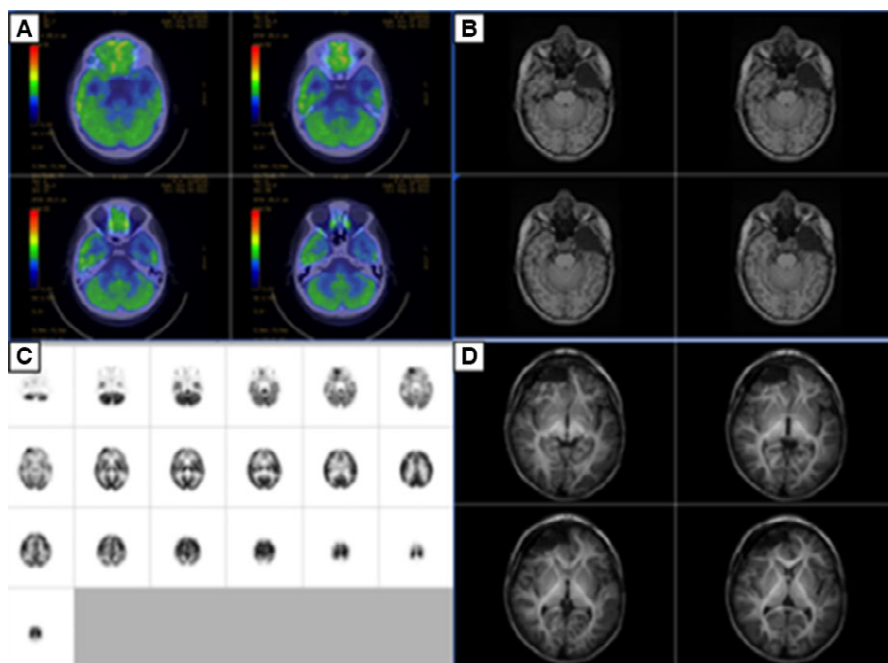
Comparison of PET and iSPECT to surgical resection. Each PET scan (A) and iSPECT study (C) was categorized as localizing if the functional abnormalities identified were resected completely (B and D). *Epilepsia* © ILAE
